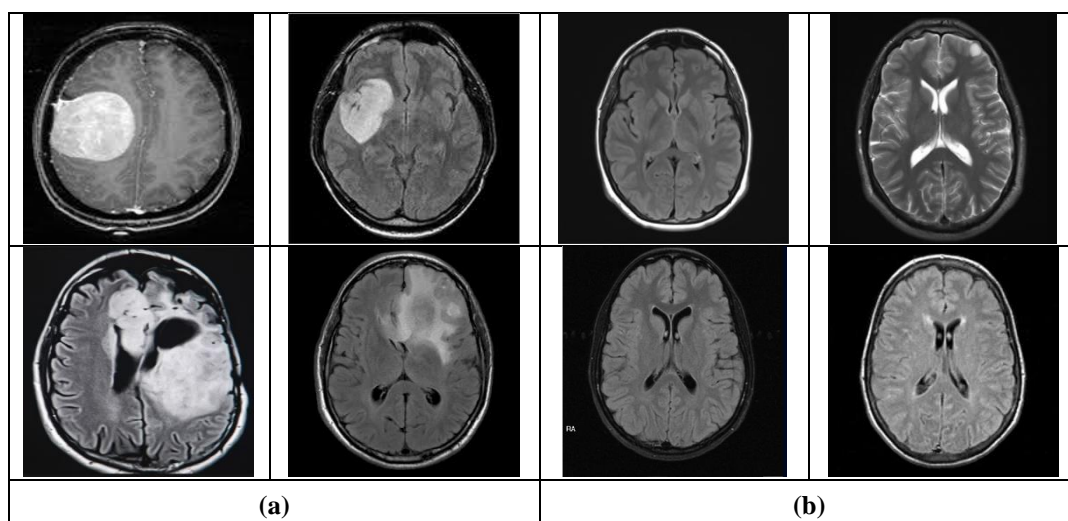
Sample images from the data set. (a) MR images with tumor and (b) MR images without tumor
